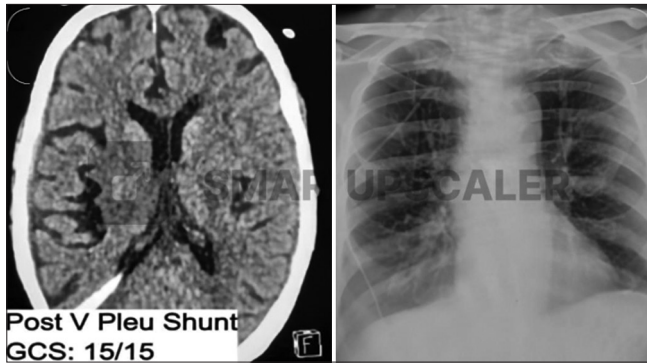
Post ventriculopleural shunt and chest X-ray showing the intrapleural. F(foot) in the image denotes direction towards which the image is being scrolled.
